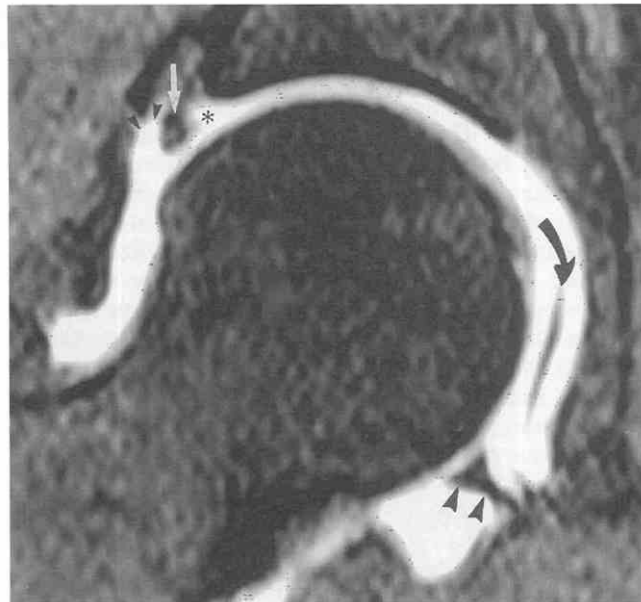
Partial superior labral detachment in a 40-year-old man. Coronal T1-weighted MRI arthrogram shows the superior labrum (arrow) with contrast at the acetabular junction (asterisk) representing partial labral detachment. Small perilabral recess (small arrowheads), ligamentum teres (curved arrow), and transverse ligament (large arrowheads) are also seen.
